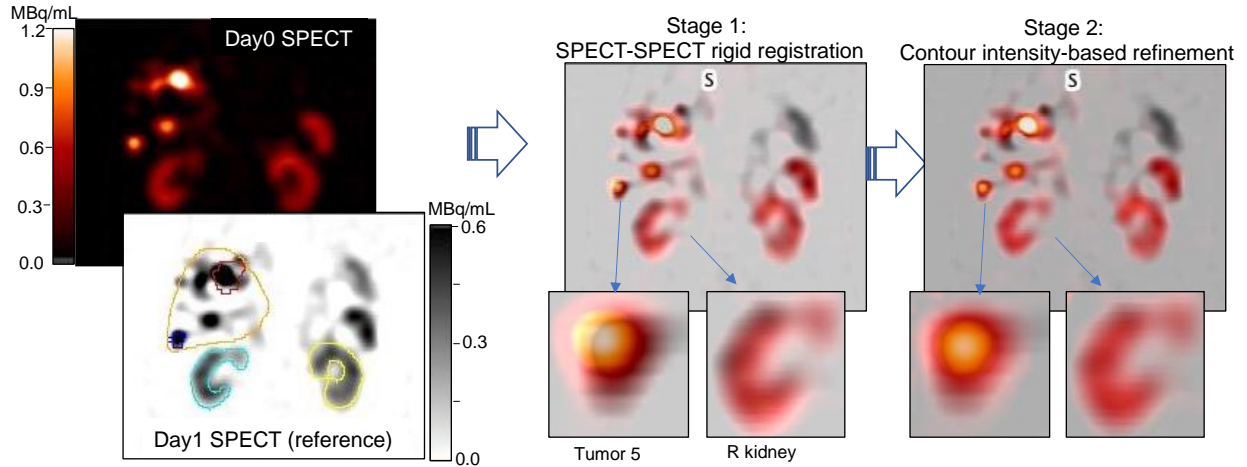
The two-stages of the automatic SPECT-SPECT registration demonstrated for patient 12 Day0 and Day1 images. Comparison of magnified inserts show subtle improvement in alignment with the contour intensity-based refinement.
